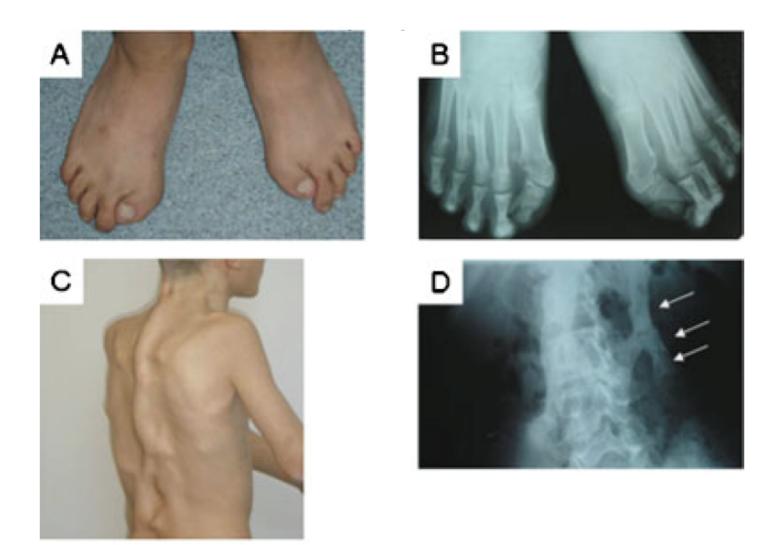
Characteristic features of FOP. A photograph (A) and radiograph (B) of the feet in an affected boy age 15 years with classic FOP show short, malformed halluces with a single, dysplastic phalanx in each great toe. A photograph of his back (C) and a radiograph of his lumbar spine (D) reveal confluent areas (plates) of heterotopic bone (D, arrows).
